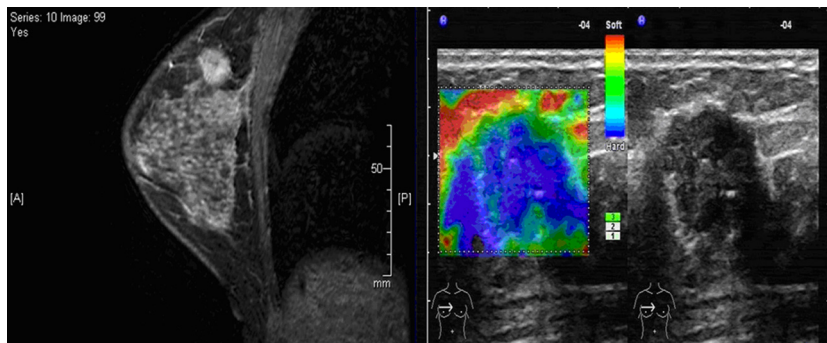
T size measured by MRI and US was consistent
